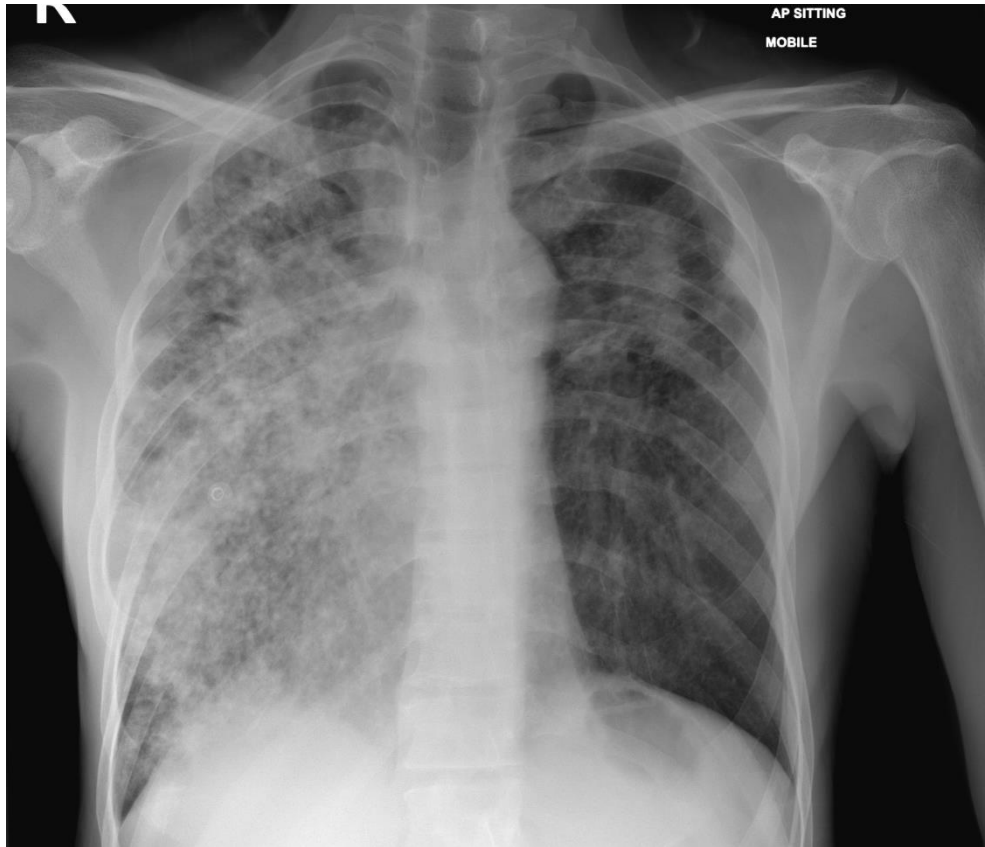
Frontal chest X-Ray showing a diffuse nodular pattern along with airspace opacities involving all the right lung. In addition, there is left upper lung zone airspace opacity along with subtle nodularity.
